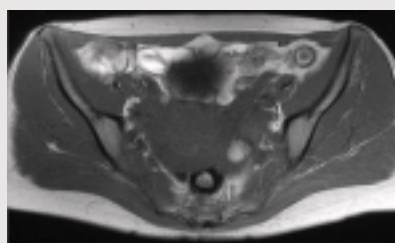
2 T1-weighted images
